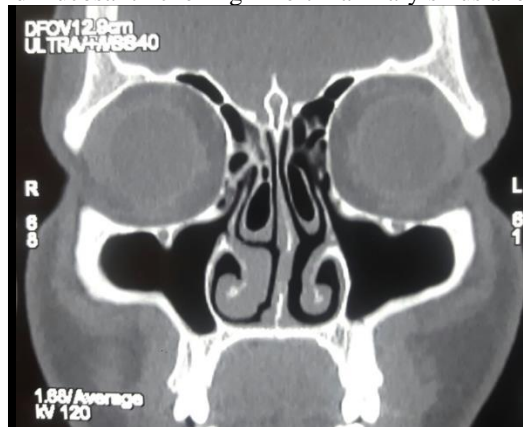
CT scan showing severe DNS left with bilateral concha bullosa along with mucosal thickening in both infundibular region and bilateral ethmoid sinus.
